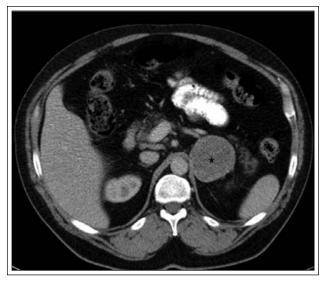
Abdominal CT scan showing large left-sided adrenal mass (with * marking the mass).
